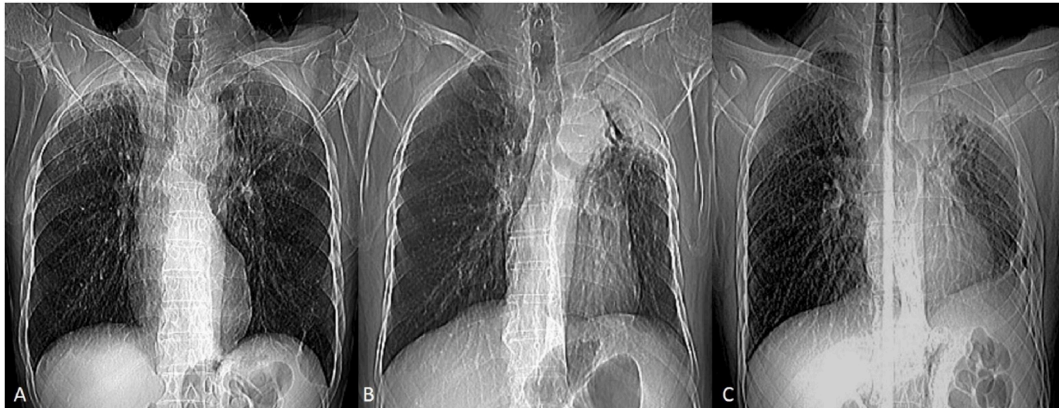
Rasmussen aneurysm 2D CT: showing radiodense opacity in right upper zone in case 1 (A), left upper zone in case 2 (B) and case 3 (C).
